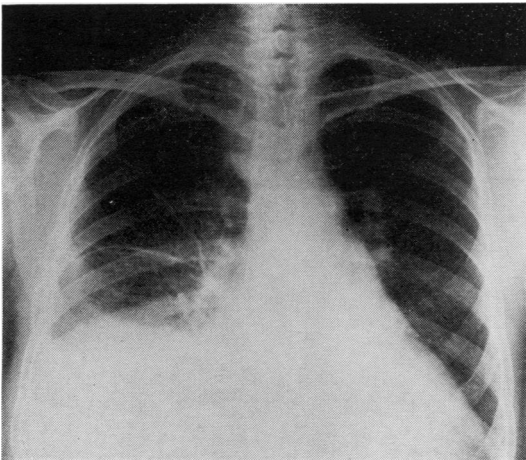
Chest radiograph showing right pleural effusion, right mediastinal mass, and enlarged left atrium.*
